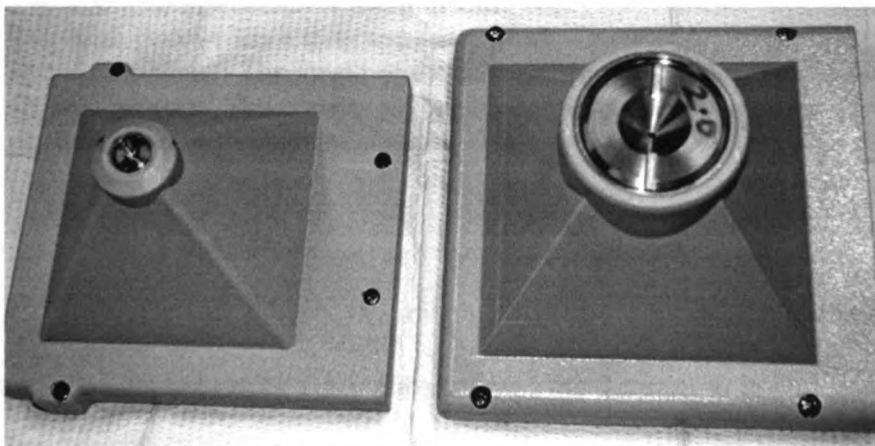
The X-SPECT has two pinhole collimators. The collimator on the left is used for lower energy isotopes such as I-125 (27.5 keV) and Tc-99m (140 keV). The collimator on the right has increased shielding, and is used for imaging higher energy isotopes such as indium-111 (171 keV, 245 keV). The pinhole inserts are removable, and can be switched to optimize the compromise between spatial resolution and detection efficiency.
